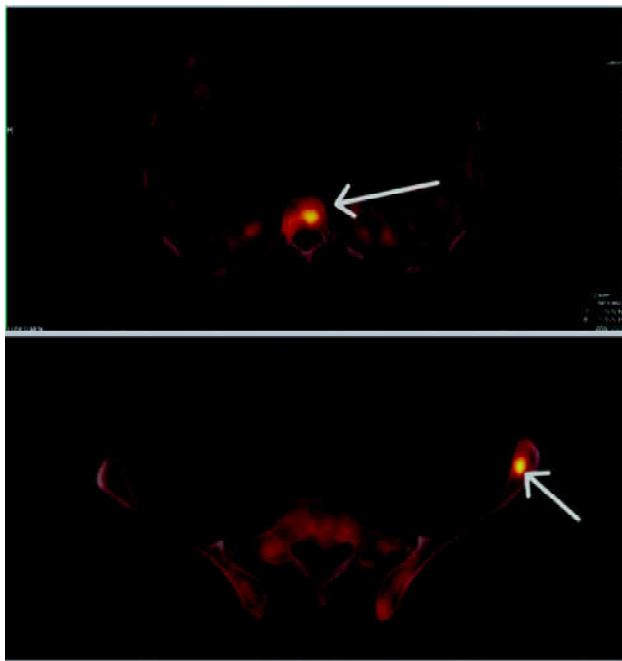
PET-CT images showing intense FDG uptake in the right ileum and thoracic vertebrae.
